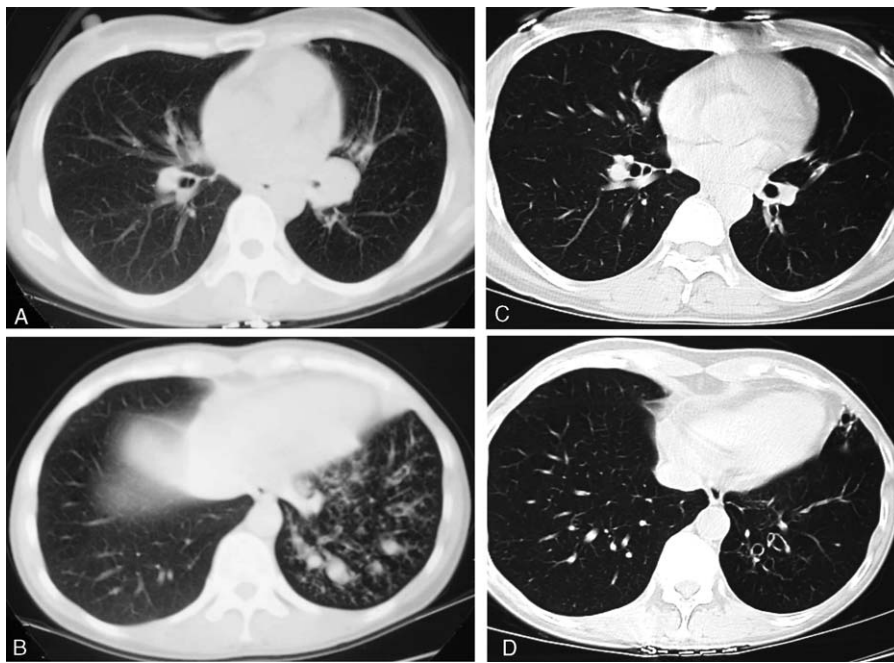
CT scans, Chest. Double contour and signet ring signs are present in left upper, lingulae, and lower lobes. There is stenosis in left lower bronchus; several multiple sharp bordered nodes are evident on the left lower lobe (A and B). Follow-up CT chest revealed severe bronchial dilatation in left lower lobe 10 years after bronchial foreign body was removed (C and D).
